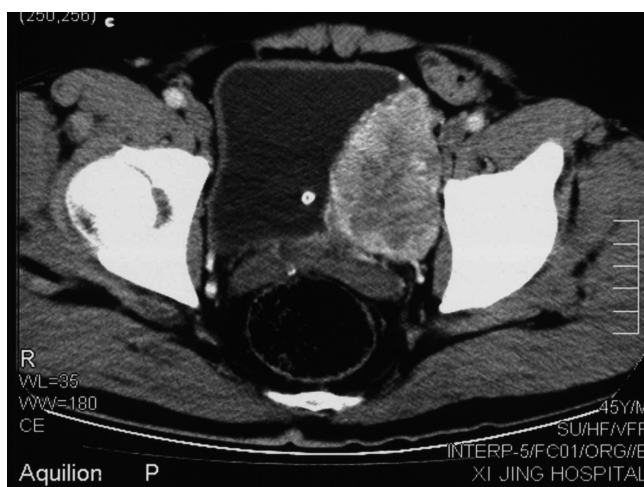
CT revealed a tumor in the left lateral wall of the urinary bladder protruding into the bladder lumen.
